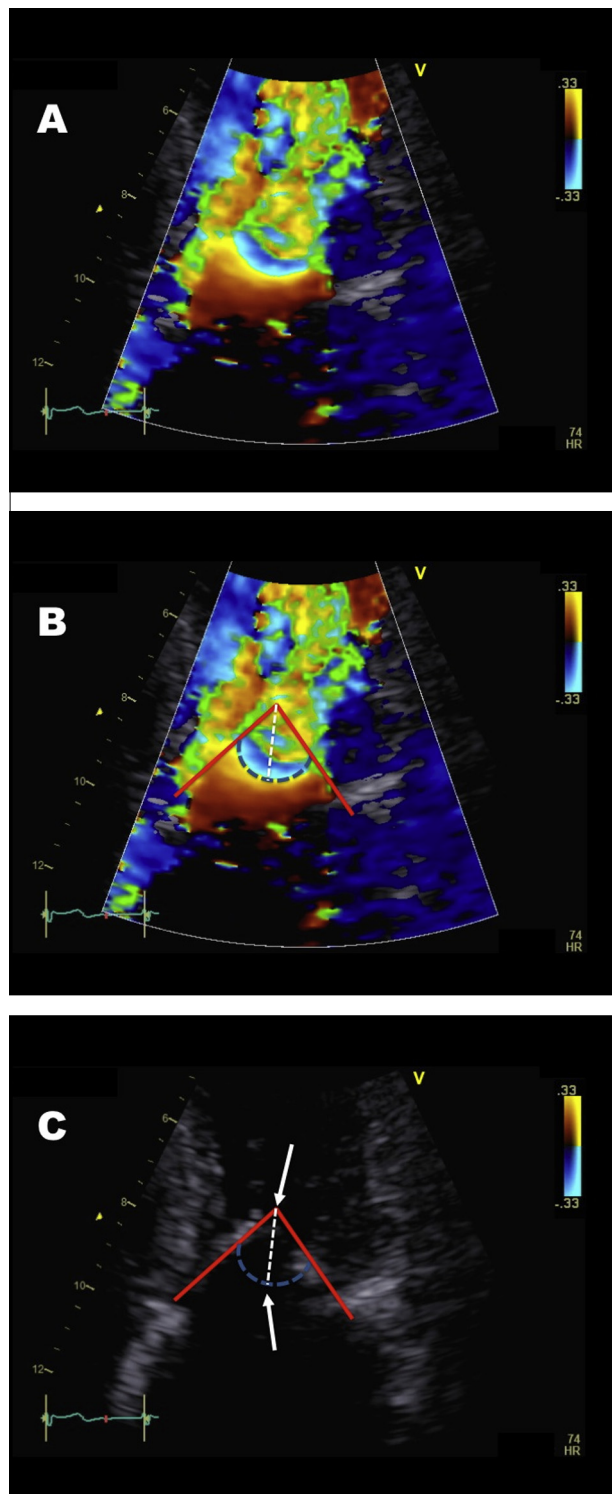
PISA-r measurement. A: the blue cap of the forward PISA flow above the mitral valve in early diastole. B: method of measuring PISA-r using imaginary lines from mitral leaflets (solid straight red line), and the red-blue aliasing border (curved dashed blue line). PISA radius is then measured between the apex of the triangle formed by the mitral leaflets (upper arrow) and the aliasing line (dashed straight white line), parallel to the mitral flow. C: Same image with color Doppler turned off to show boundaries of measurements.
